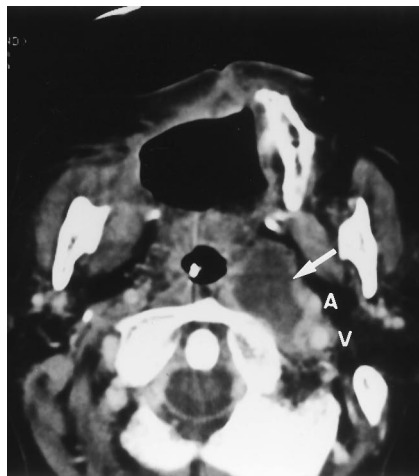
72-year-old woman with squamous cell carcinoma of the upper gingiva (rT2N0M0). Contrast-enhanced axial CT scan shows a progressively enlarged low-attenuation nodal mass,  $28 \times 24$  mm, with a poorly defined rim, indicating lateral retropharyngeal node metastasis (arrow). The internal carotid artery (A) and jugular vein (V) were displaced laterally by the node.
